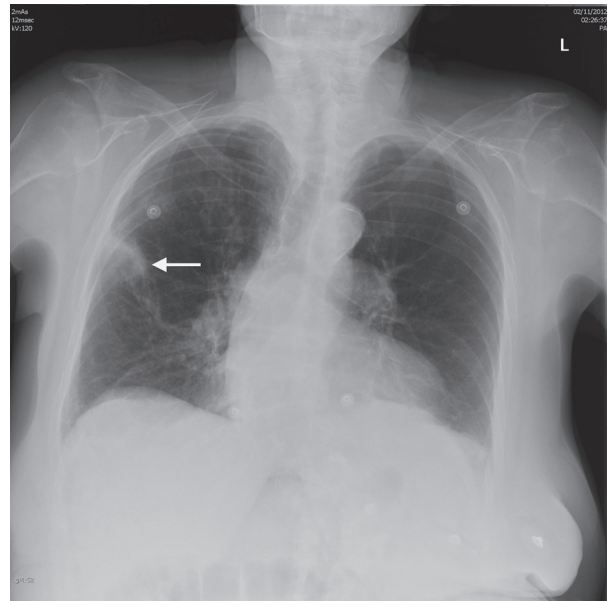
Posterior-anterior chest radiograph. Hampton's hump (arrow) is a classic sign of PE.
